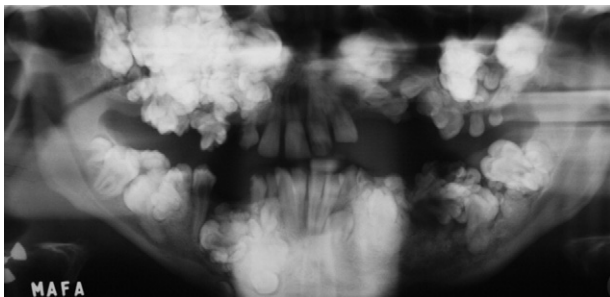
Panoramic radiograph, multiple tooth-like opacities in the jaws.
